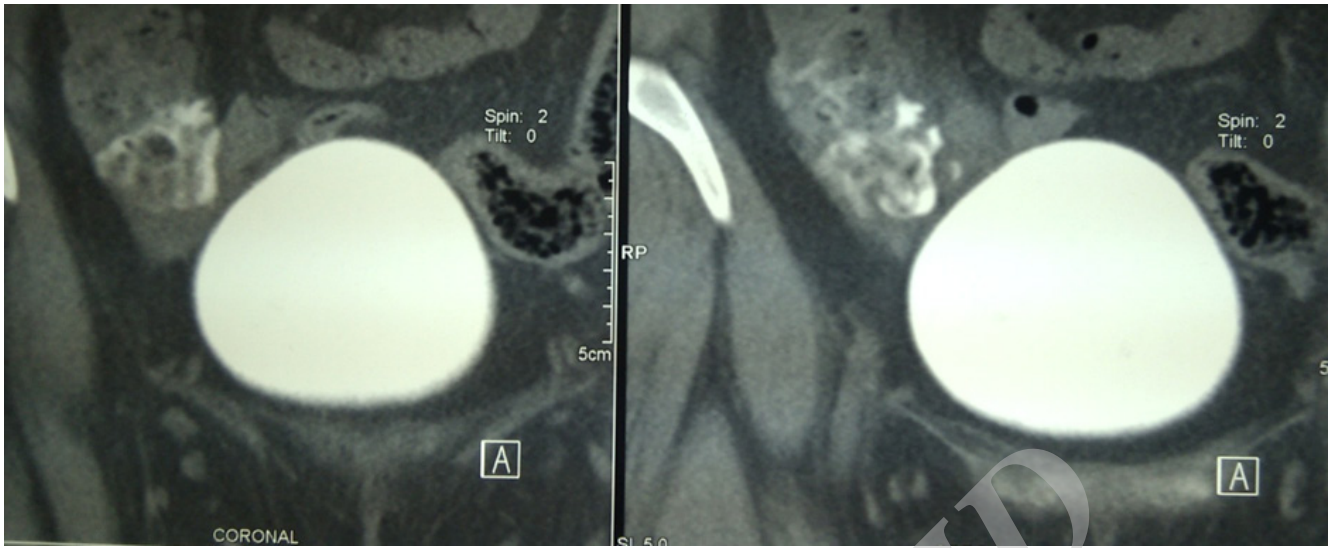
Coronal view of cecum, bladder and fistula in computed tomography cystography.
